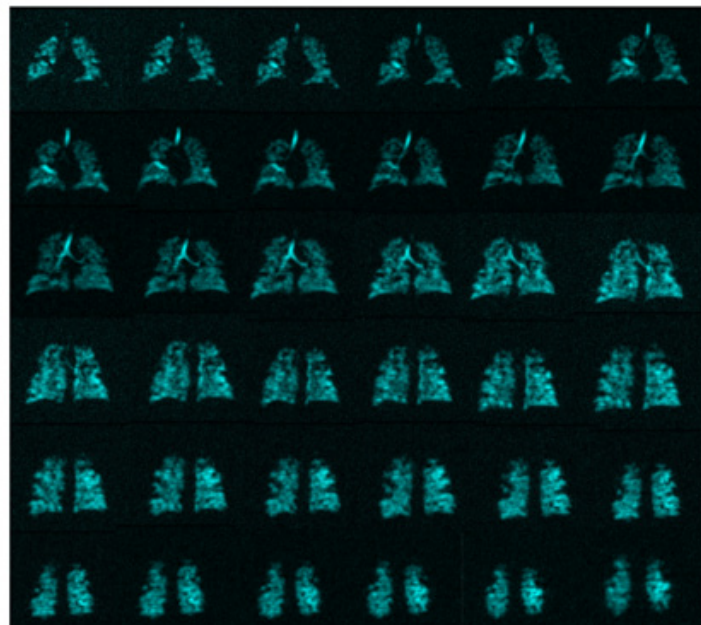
Representative coronal 80 slice ^{129}Xe MRI images.
